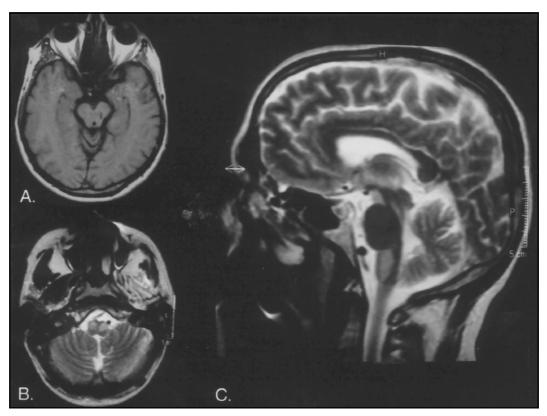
MRI 5 months after the hemorrhage: T1-weighted axial image (A) shows a residual tuft in the midbrain. Axial and sagital images (B and C) shows increased signal intensification in the area of the olives on T2, greatest in the left. Enlargement of the inferior olivary nuclei was also noted.
